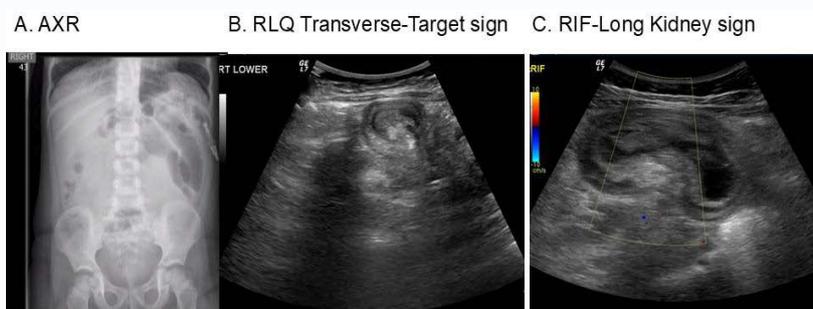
A. Abdominal radiograph showing dilated jejunal ileal loops with scanty gas in the distal bowel and soft tissue mass in the right side, B. USS transverse view of right lower quadrant showing typical target sign with layers of bowel, C. USS longitudinal view of right iliac fossa demonstrating clear kidney sign.
